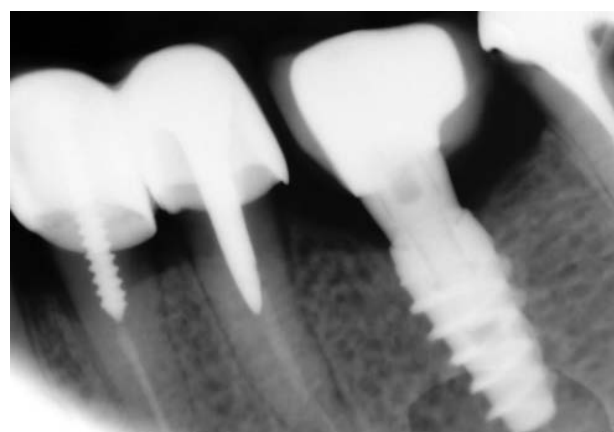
Radiographic image taken in cementation session
